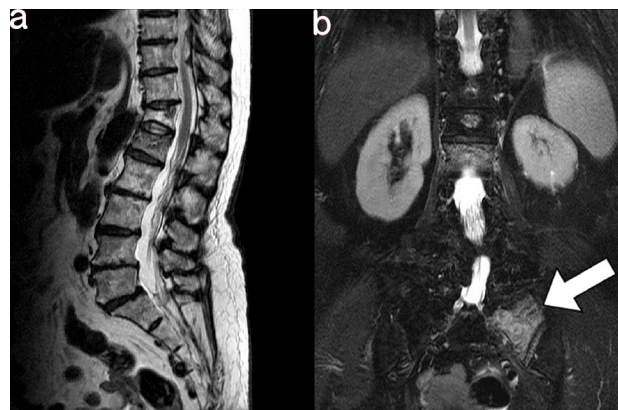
MRI (a, T2-weighted sagittal view; b, T2-weighted coronal view) of an 76-year-old woman with sacral insufficiency fracture. SIF involve left alar area (white arrowheads)
